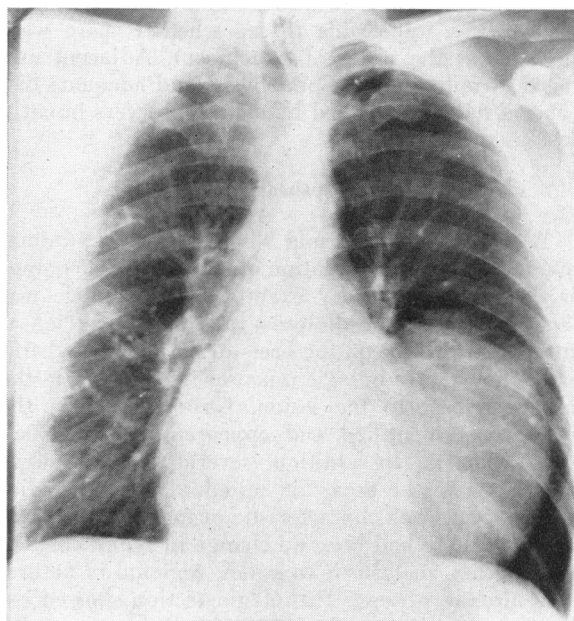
Preoperative x-ray film showing large left ventricular aneurysm.
